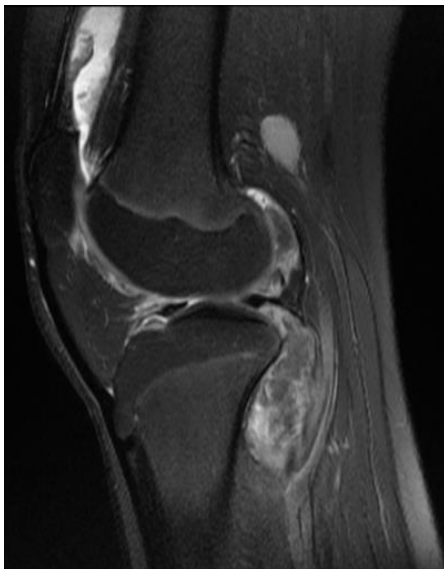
Sagittal T2 Weighted Magnetic Resonance image of the knee with a large effusion and villous proliferation arising from the synovial lining
